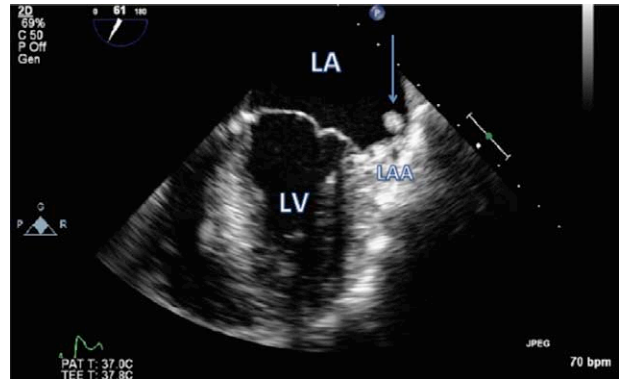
A transesophageal image of an endocardial left atrial pedunculated thrombus (arrow) seen 3 months after left atrial appendage closure. LA indicates left atrium; LAA, left atrial appendage; and LV, left ventricle.
